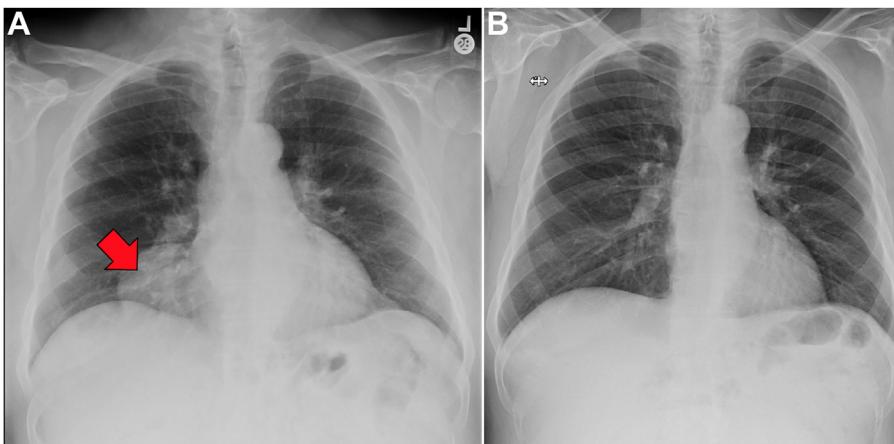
Preoperative (A) and Postoperative (B) chest X-rays from repaired simple Morgagni hernia. Red arrow shows mediastinal hernia contents before repair.
